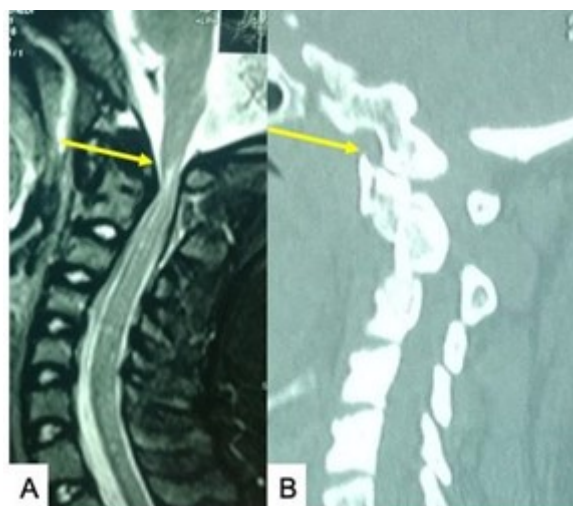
(A) MRI of CVJ showing high cervical spinal cord compression due to craniocervical junction instability. (B) CT scan of CVJ in the same patient showing condylar joint or atlanto-occipital dislocation (AOD) (marked with an arrow). Source: Figure by authors.
